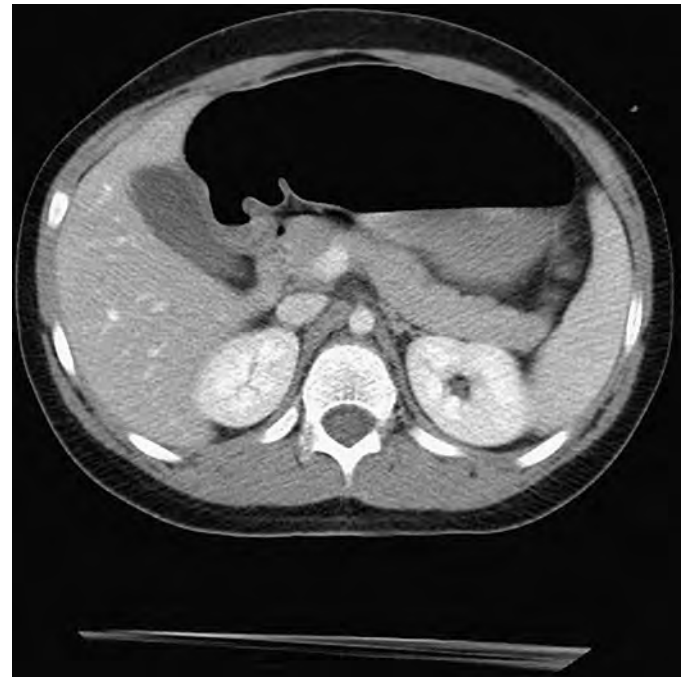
Normal pancreas. The contrast-enhanced CT scan demonstrates a normal pancreas with a gently lobulated surface in a 7-year-old girl. The attenuation of the pancreas is similar to that of the adjacent liver.
